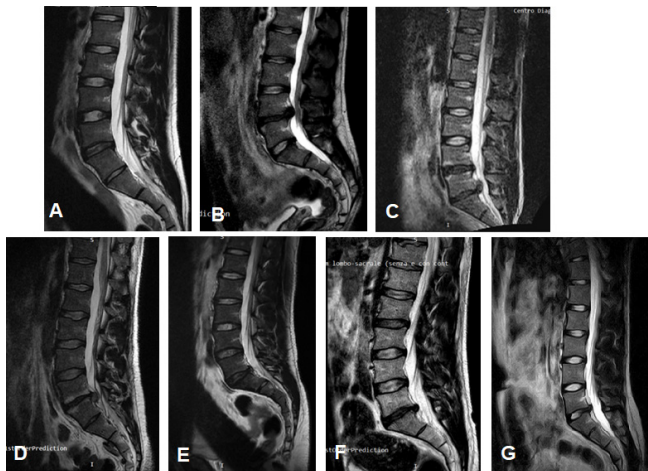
MRI of the patients.
